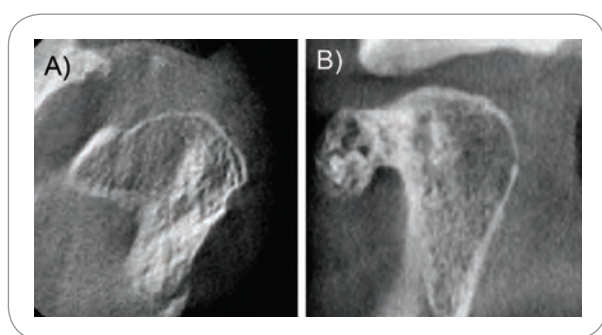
Osteochondroma on axial (A) and lateral (B) CBCT sections showing an exophytic lesion located on the anterior surface of the condylar head. These images show the continuity of the normal condylar trabeculation with the tumor.
